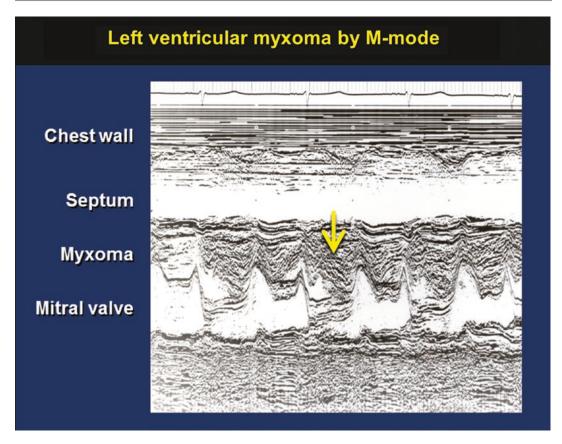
M-mode echocardiogram of a left ventricular myxoma that obliterated the left ventricular outflow tract (arrow)
